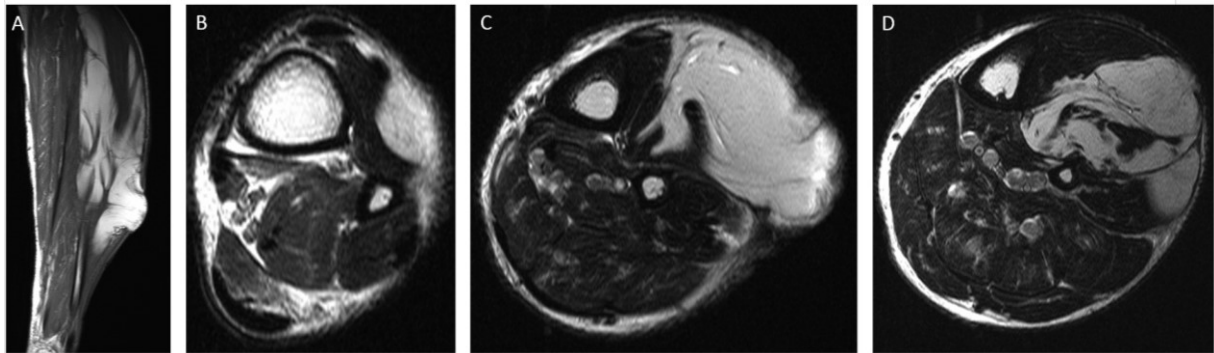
Sagittal T1-weighted MRI scan of an atypical lipomatous tumour at the left lower leg with area of “fungation” (A). Transversal T2-weighted MRI scan of the same patient, at the level of the distal syndesmosis (B). Transversal T2-weighted MRI scans at the level of the “fungating” tumour area (C) and further proximal (D).
